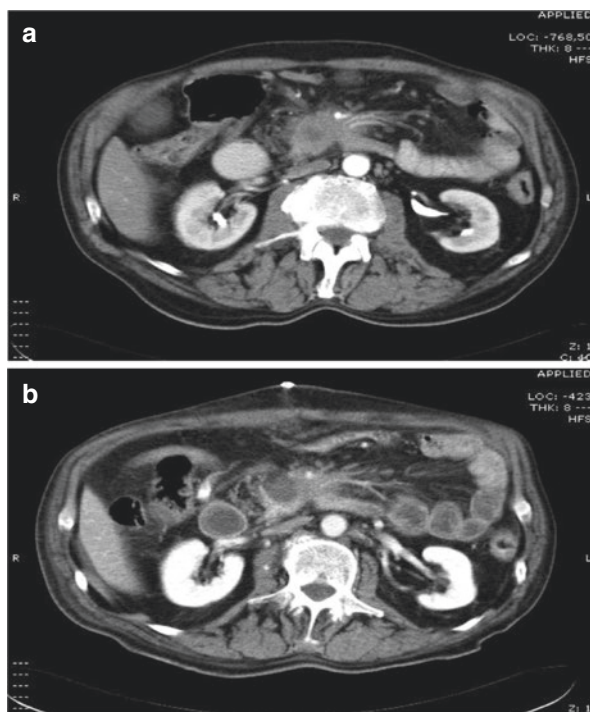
(a) Preoperative CT scan: locally advanced pancreatic cancer (3 cm) of the uncinate process and (b) ablation area with adequate safety margins – CT scan after 1 month
